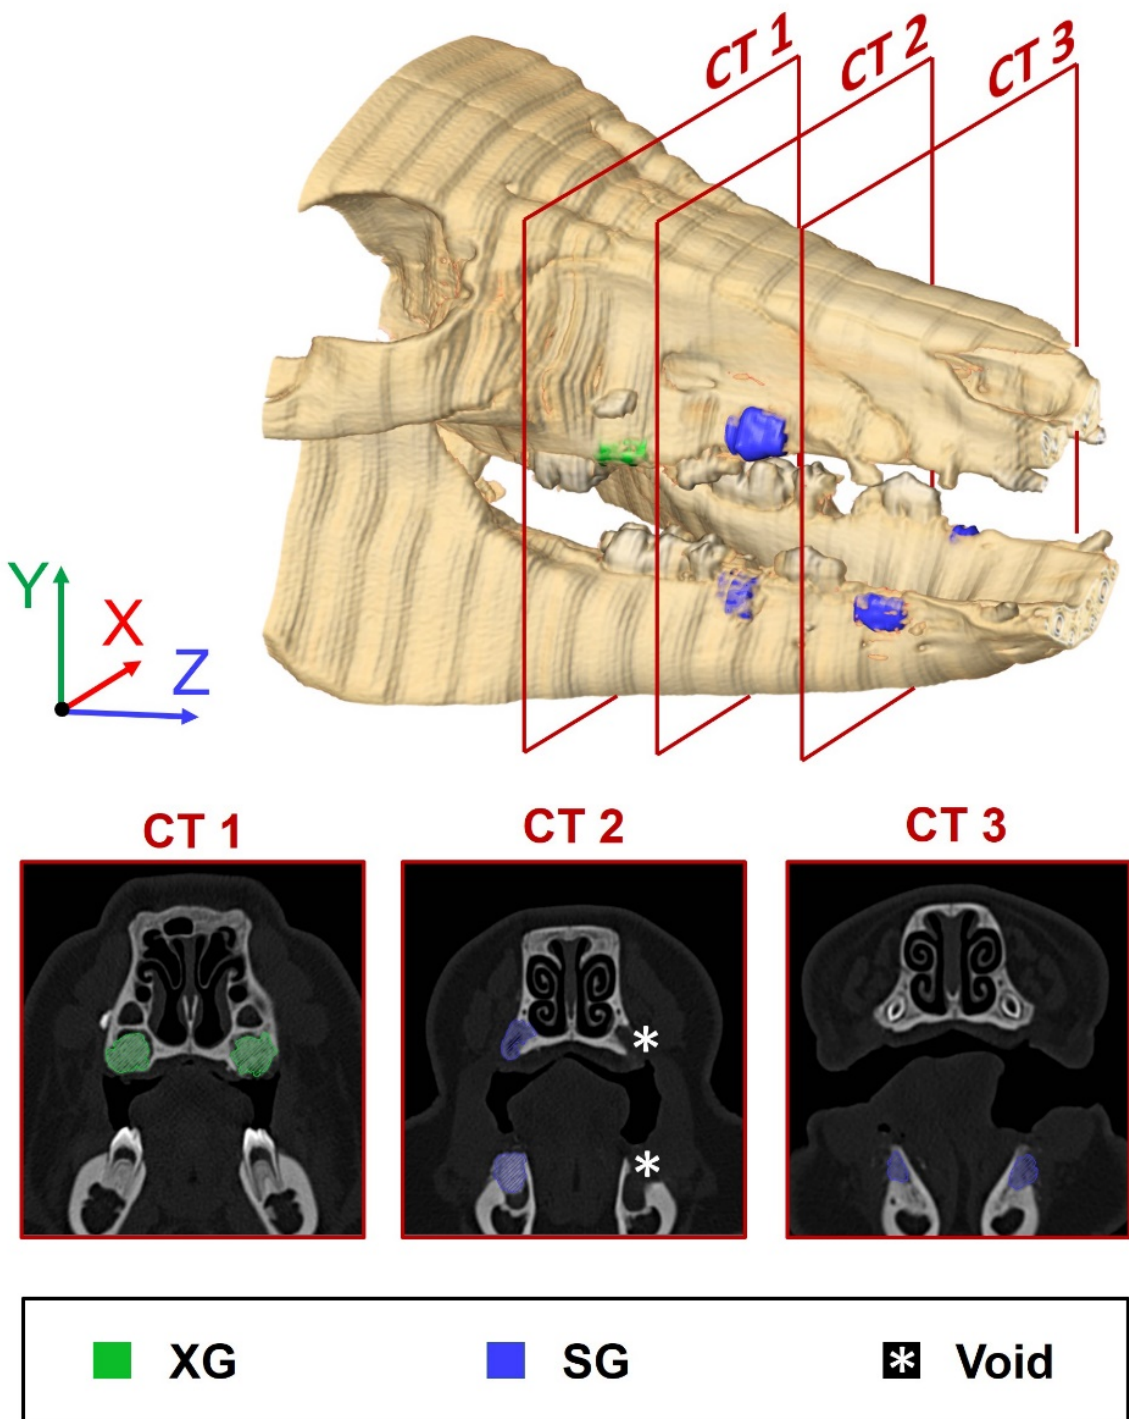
Top: Reconstruction of the CT scan and grey-values 3D segmentation of the different three-wall bone defects. Bottom: Three representative slices of the CT scan representing the segmentation of the different bone substitutes.
